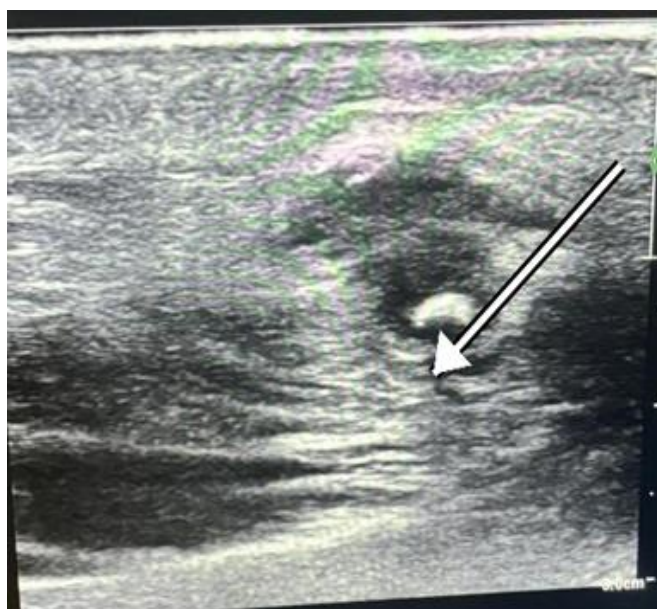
Ultrasonography image showing an echogenic distal parotid duct calculus with posterior acoustic shadowing (arrow).
